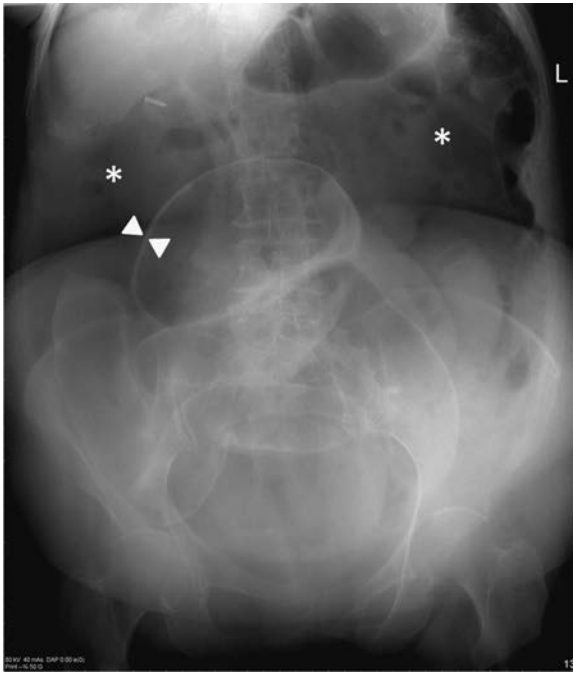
Abdominal X-ray. Extensive pneumoperitoneum with free gas in the upper abdomen (*) and Rigler's sign (arrowheads, pointing out air on both sides of the bowel wall).
